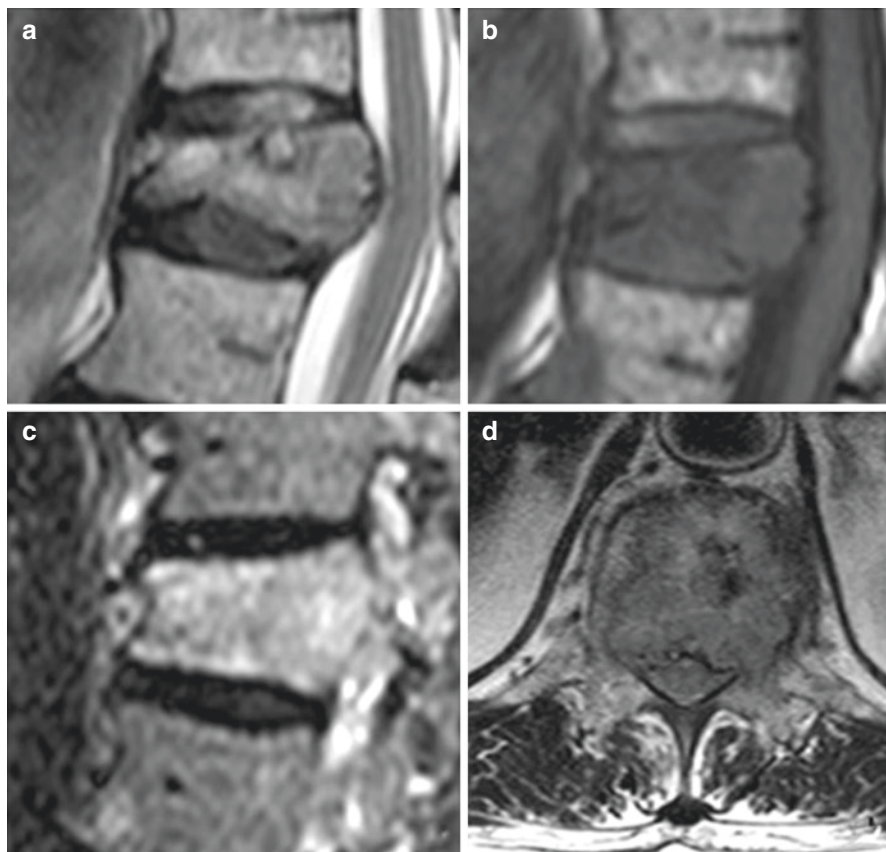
MRI of the same patient: sagittal T2 weighted (a), sagittal T1 weighted (b), short-tau inversion recovery (STIR) (c), and axial T2-weighted (d) images show the osteolytic lesion, which caused vertebral collapse
